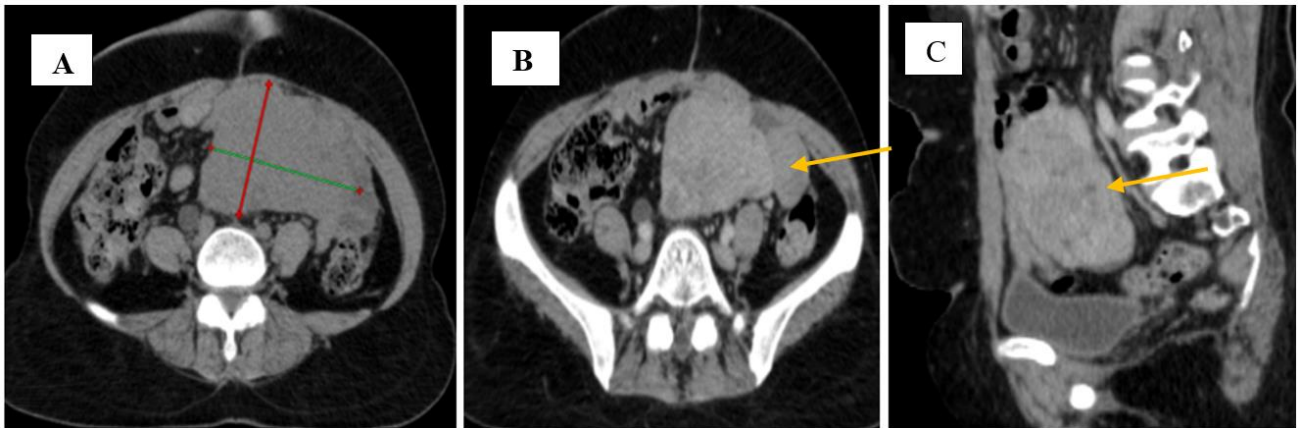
Abdominal CT scan without and with injection in axial (a and b) and sagittal (c) sections: supravescical mass lateralized to the left, isodense to spontaneous contrast, heterogeneously enhanced, showing intimate contact with the intestinal anse and anterior abdominal wall
